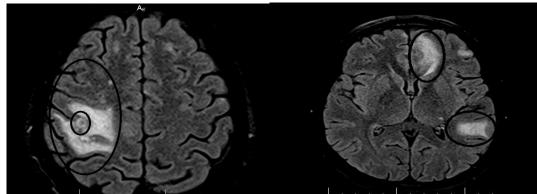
Images in axial slices describe several nodular images with central FLAIR isosignal and hypersignal peripheral ring with isosignal T1, without restriction diffusion nor contrast outlet
